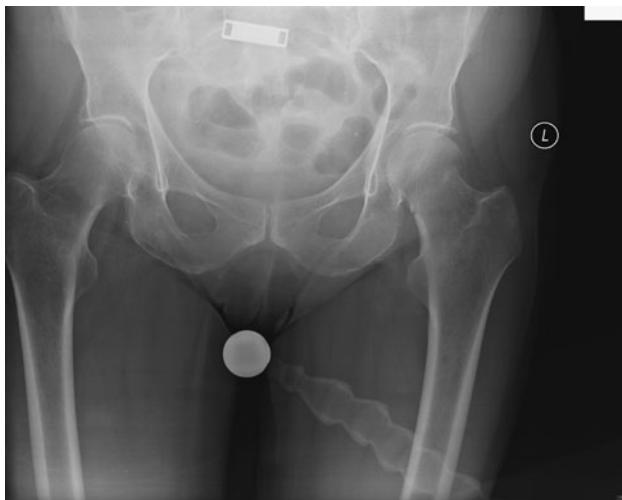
AP radiograph of an intracapsular fractured neck of femur on the *left side*. The joint capsule extends from the acetabulum to the intertrochanteric line anteriorly and to the junction of the middle and distal thirds of the femoral neck posteriorly. Subcapital fractures are therefore intracapsular injuries. This distinction is important because intracapsular fractures are more prone to osteonecrosis because the blood supply to the femoral head originates from the circumflex femoral arteries
